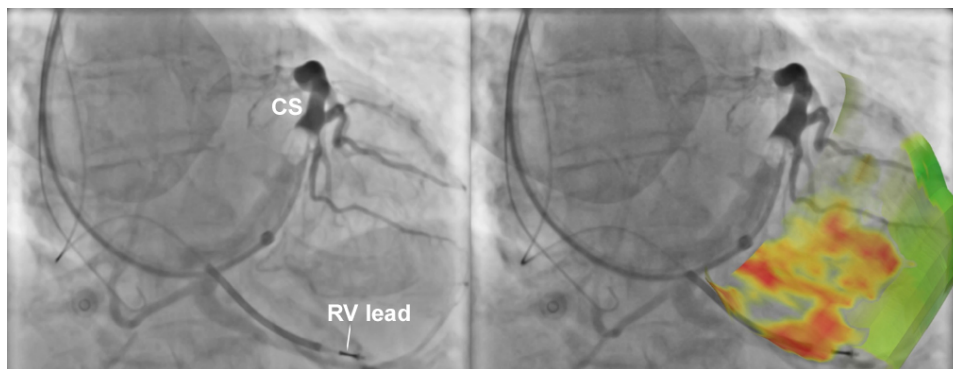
Fusion of 3D-cardiac magnetic resonance data with live-fluoroscopy. Fluoroscopic projections made during CRT implantation (left) with visualization of the coronary venous system/coronary sinus (CS) and the right ventricular (RV) lead. LV leads are placed in a tributary of the CS overlying the LV epicardium. Intra-procedural visualization (right) of scar transmurality (red-yellow) and delayed LV activation (green) derived from cardiac magnetic resonance imaging may help to guide the LV lead towards an optimal site for LV stimulation.
